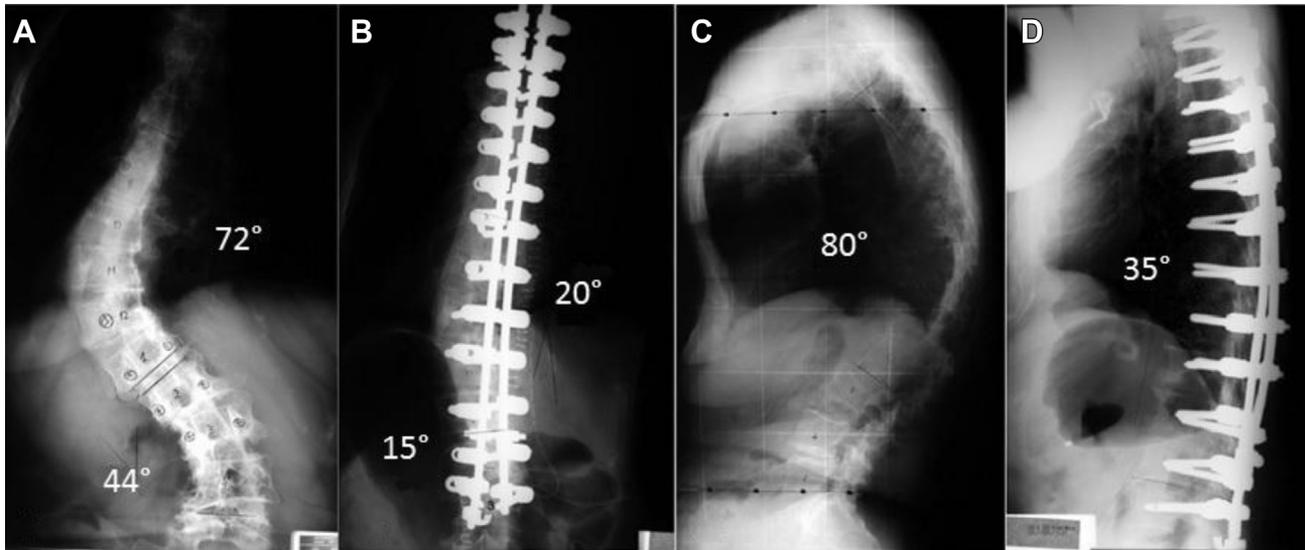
A 69-year-old female patient. Severe postmenopausal kyphoscoliosis with marked worsening over the last years. Correction consisted in 12 levels of asymmetric Ponte osteotomy and an all-segmental construct with 26 pedicle screws from T2 to L3 in moderately porotic bone. (A) Preoperative standing AP radiograph. (B) Standing AP radiograph 24 months after surgery. (C) Preoperative standing lateral radiograph. (D) Standing lateral radiograph 24 months after surgery. AP, anteroposterior.
